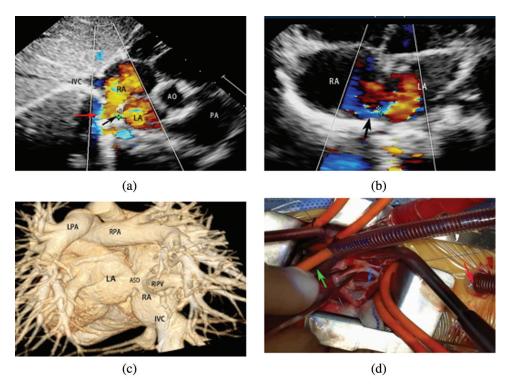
Posterior ASD in a 4-year-old boy with right pulmonary veins connected to RA. (a) Subcostal sagittal view demonstrated that right inferior pulmonary vein connected to RA with a posterior ASD. There was no posterior rim between ASD and posterior atrial wall. Red arrow indicates right pulmonary vein, black arrow indicates posterior ASD. (b) Apical four chamber view of posterior ASD. Black arrow indicates posterior ASD. (c) Volume-rendered CT image of right pulmonary veins anomalous connection with a posterior SVD. ASD was neither adjacent to SVC nor to inferior vena cava. (d) Opened-up RA showed that posterior ASD without posterior rim (blue arrow) was neither adjacent to superior vena cava nor to inferior vena cava. Red arrow indicates inferior vena cava cannula and green arrow indicates superior vena cava cannula (ASD, atrial septal defect; RA, right atrium; SVD, sinus venosus defect)
